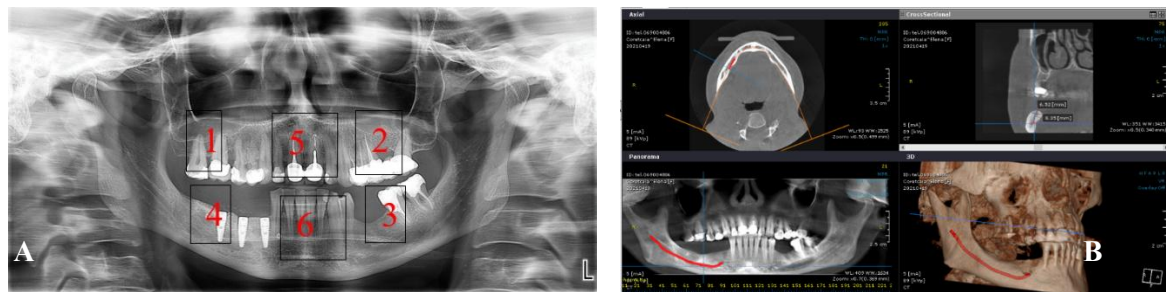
Radiological examination figure A -OPG indicating the sites that underwent regeneration and figure B CBCT section at the level of the mandible
